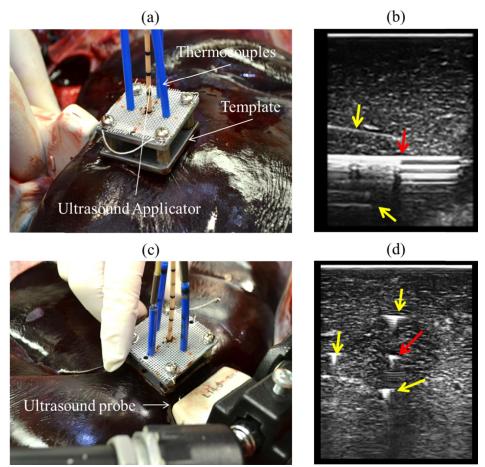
(a) Ultrasound imaging plane parallel to applicator, (b) B-mode image corresponding to imaging transducer position in (a), (c) ultrasound imaging plane perpendicular to applicator and thermocouples, and (d) B-mode images for corresponding imaging array position shown in (c). (The red and the yellow arrows in the B-mode images (b) and (d) represent the ultrasound applicator and thermocouples, respectively)
